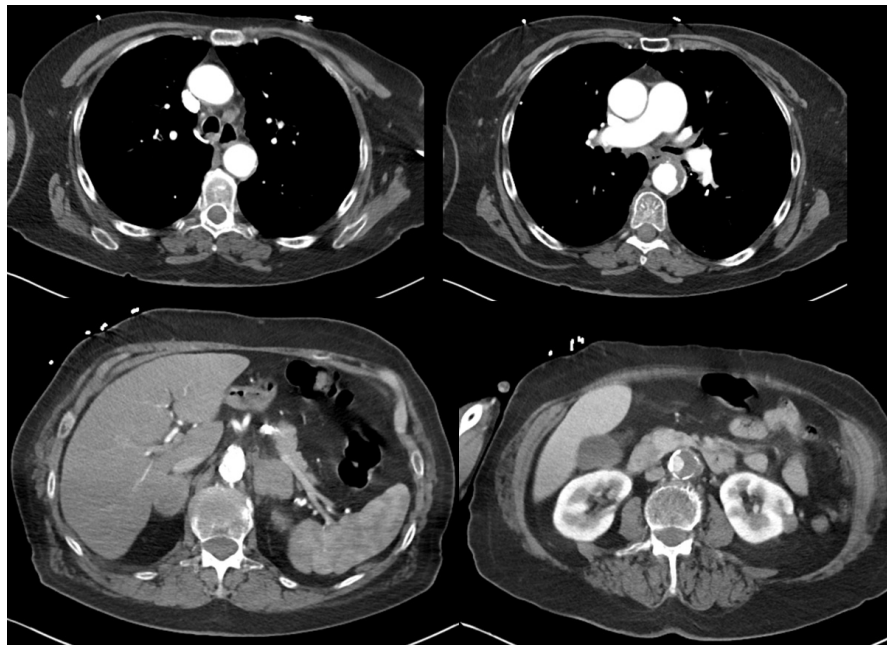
Computed tomography of the chest, abdomen, and pelvis. The lungs reveal no obvious pathology (A). Large bilateral adrenal nodules measure up to 3.9 cm on the left and 3.5 cm on the right. There is also an intermediate-density lesion in the lower pole of the left kidney (B).
